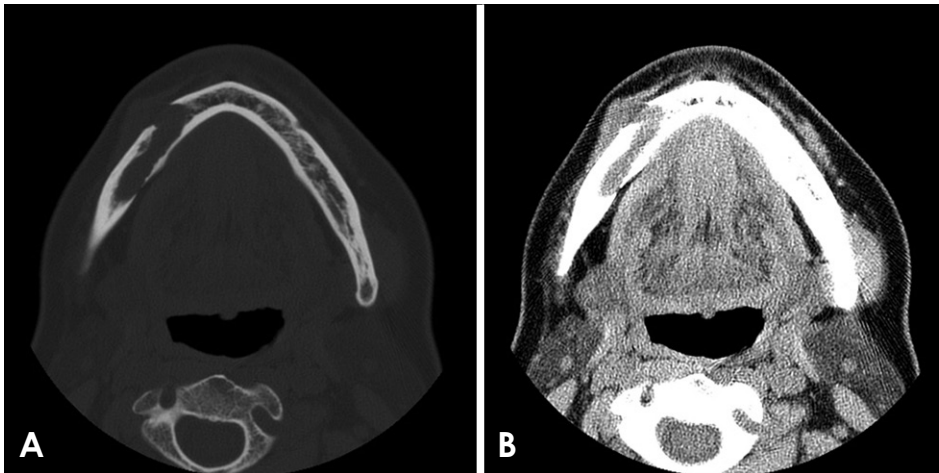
A. A computed tomographic image reveals osteolytic destruction by an expansile, 2.0 cm × 1.2 cm soft-tissue mass involving the outer cortex of the right mandibular body. B. The lesion is shown on the soft-tissue computed tomographic image.
